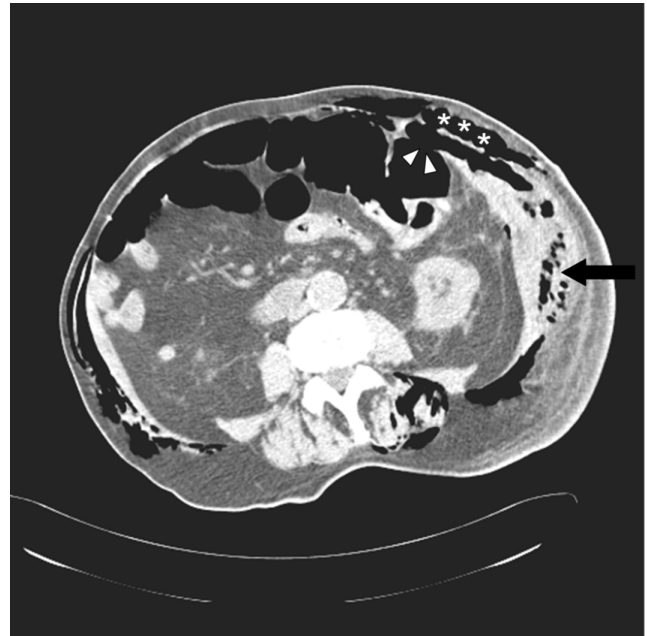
80-year-old man with massive subcutaneous emphysema. Abdominal CT at the level of the left kidney shows the colocolic fistula (arrowheads) and abscess of the abdominal wall (arrow). Subcutaneous emphysema is also present at this level (asterisks).
